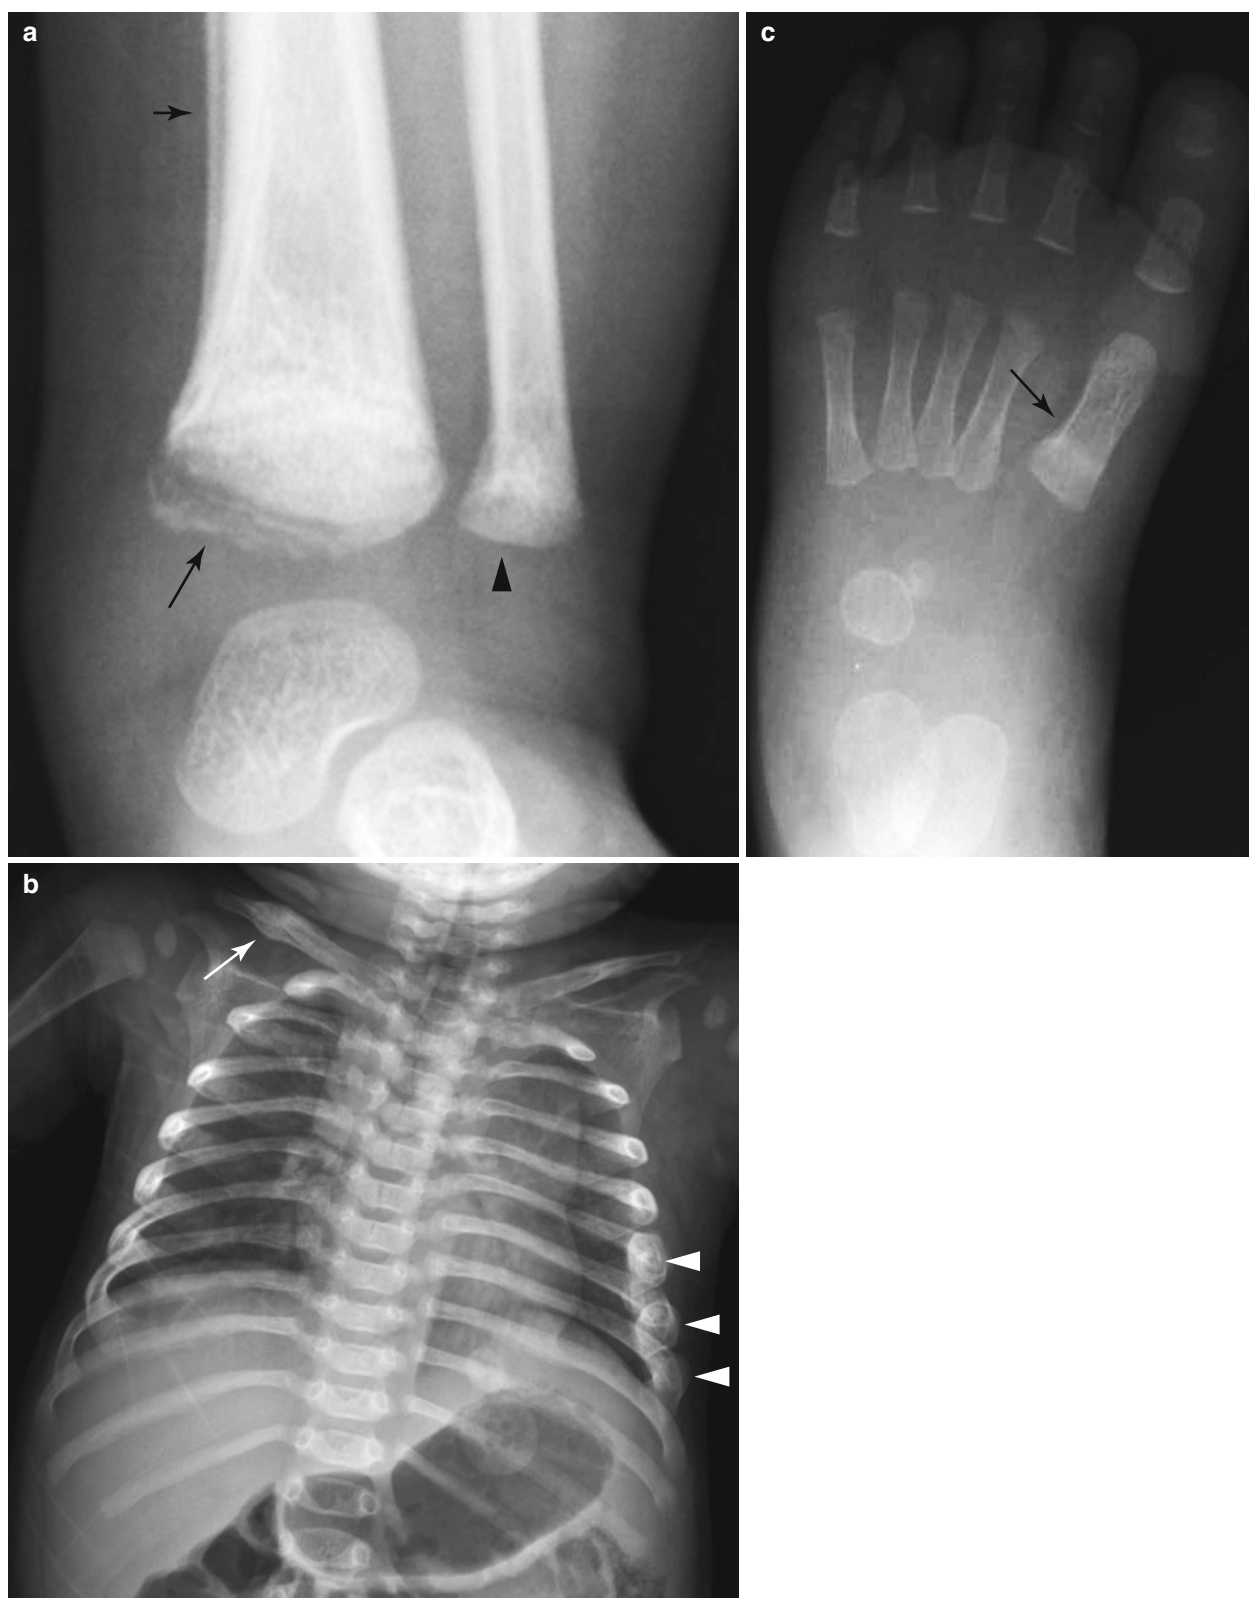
Skeletal findings of child abuse.* (a) Classic metaphyseal lesion in an abused 7-month-old boy. Anteroposterior radiograph of the ankle shows a rim of bone (*long arrow*) separated from the tibial shaft by the lucent metaphyseal fracture. There is subtle periosteal bone along the medial tibial shaft (*short arrow*). Classic metaphyseal lesion of the distal fibula is also faintly seen (*arrowhead*). (b) Multiple rib
